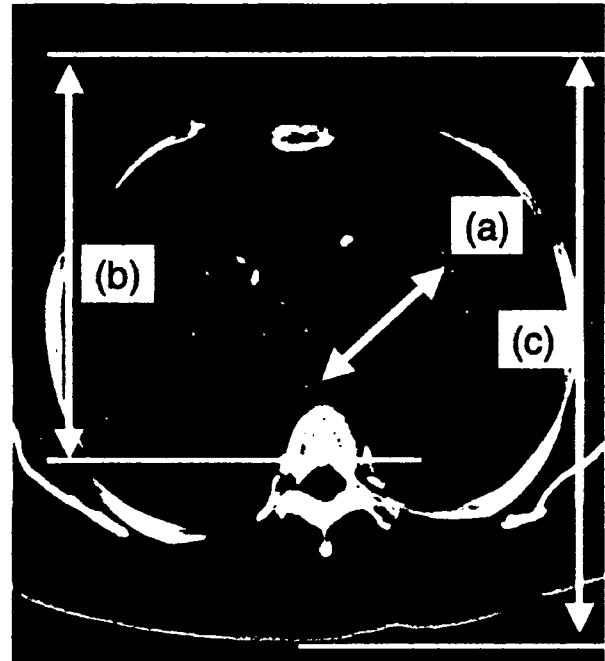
The diameter of aneurysm (a), the depth of distal end of aneurysm from anterior body surface (b), and the anteroposterior diameter of body trunk (c), was measured by computed tomography.
